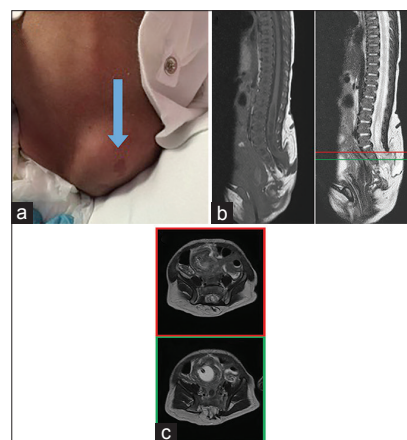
(a) Photograph demonstrating a lumbar mass and associated hyperpigmentation. (b) T1 (left) and T2 (right) sagittal sections of an MRI showing the lumbosacral dysraphism and associated cystic lumbar mass. (c) Selected T2 axial sections as identified by color coding on the sagittal image in A
